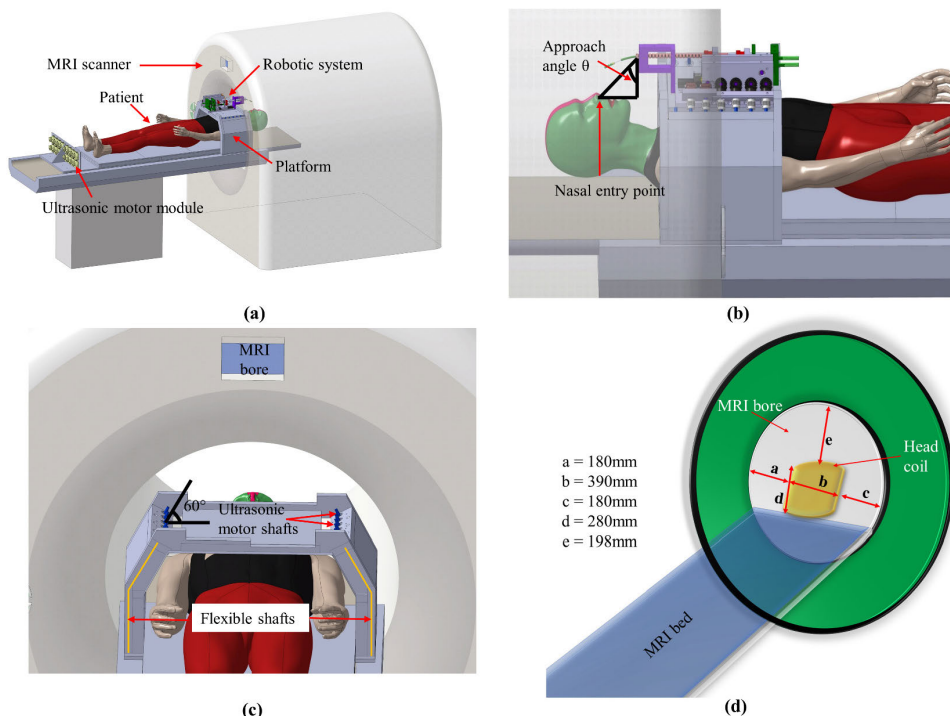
3D model of the whole surgical system; (a) robotic system integrated with MRI compatible motor system and inserted in the bore of 3T MR scanner, (b) surgical constraint for insertion in the nasal cavity of the patient, (c) geometric constraints for the robotic system and (d) measured rough dimensions of the Siemens 3T MRI bore.
